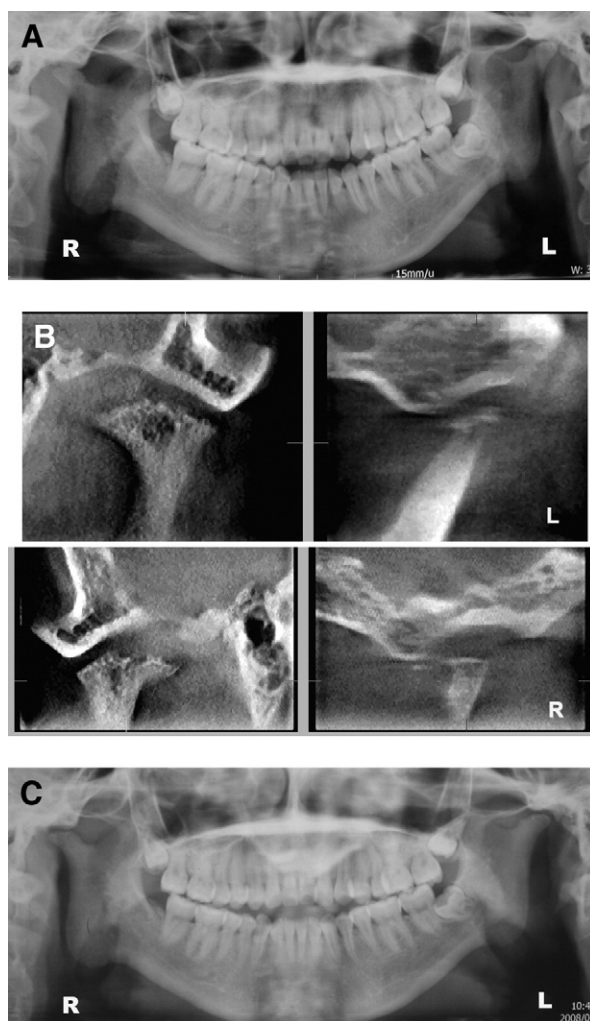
Samples of a representative 18-year-old woman is shown. A, Preorthodontic radiographic examination (panoramic radiogram) showed shortening of the bilateral condyles with anterior open bite. B, Cone-beam CT showed a bilateral shortened condylar process with decreased head bulge and cortical erosion. C, OA changes of condyle remained stable in the same patient 12 months later.
